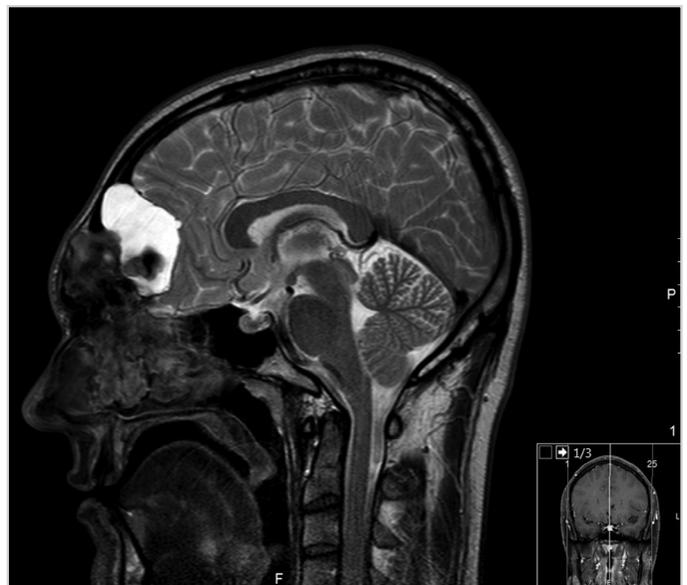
MRI images (sagittal plane) were also suggestive of a concomitant frontal mucocele
